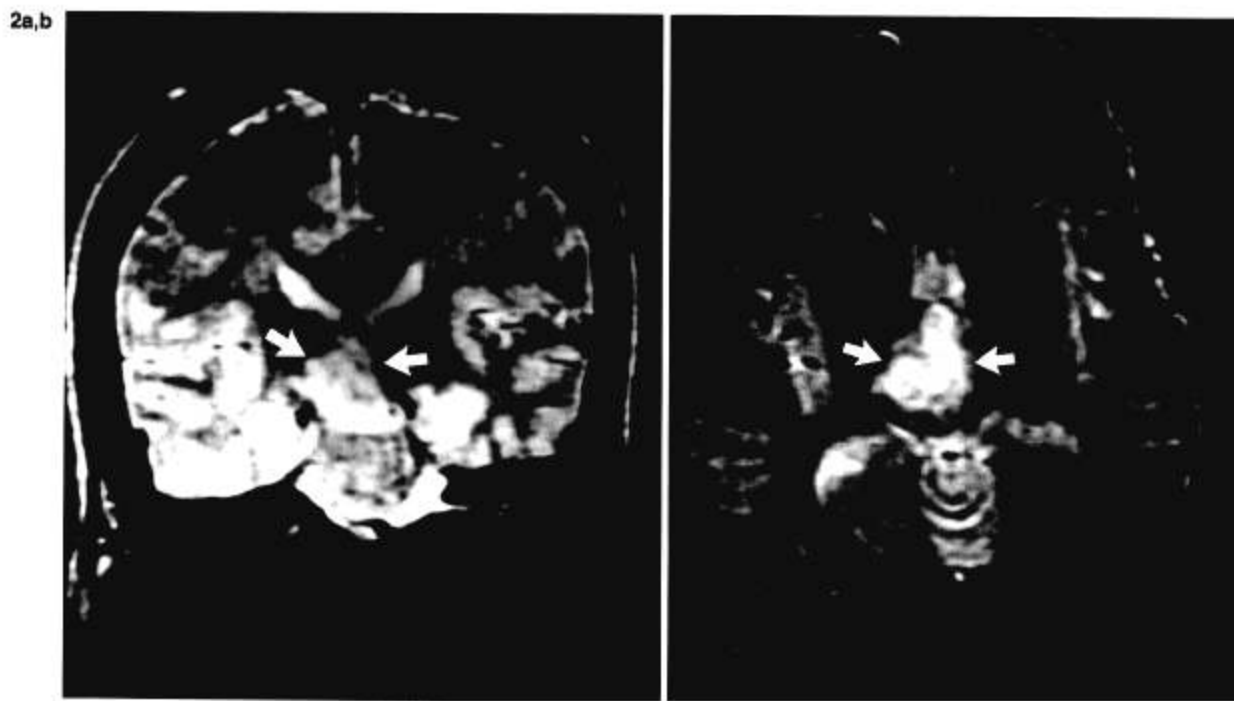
T2-weighted (TR 2,000, TE 70) coronal image (a) axial image (b) demonstrate high signal lesion involving midbrain and thalami on both sides (arrows), more on the right than left. Patient was experiencing subacute attack of meningoencephalitis characterized by dementia and amnesia.
